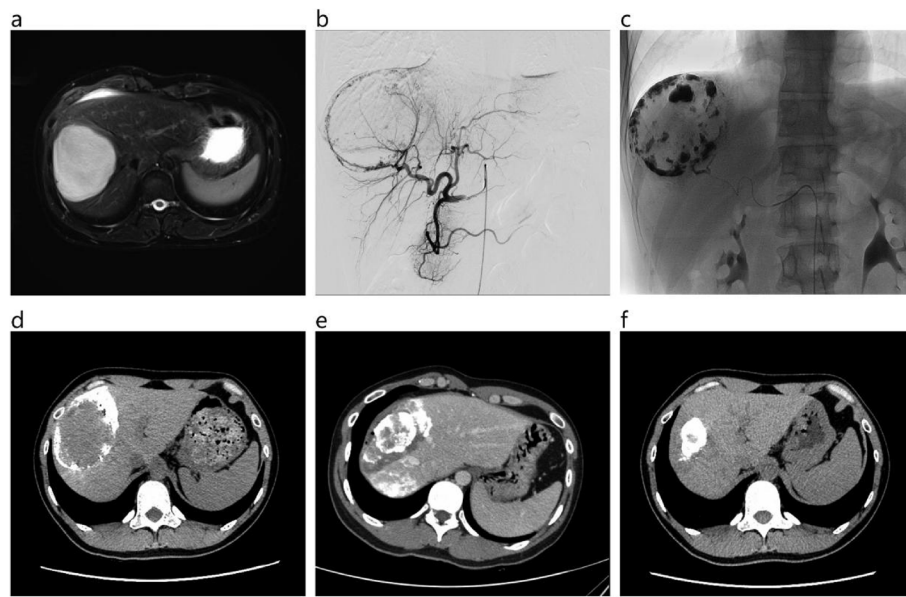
A 28-year-old man presented with a hepatic hemangioma and rapidly enlarged for 2 years. The size of the HH in the S8 segment was about 88.8*71.3 mm in the preoperative MRI (A). DSA shows the right hepatic artery supplying blood, which was embolized with lipiodol combined with gelatin sponge (B, C). Four days after intervention, abdominal CT showed lipiodol deposition in the arterial supply of the HH border (D). CT showed complete ablation of HH after RFA (E). 4 months after surgery, HH can be seen shrinking to about 50*40 mm (F)
